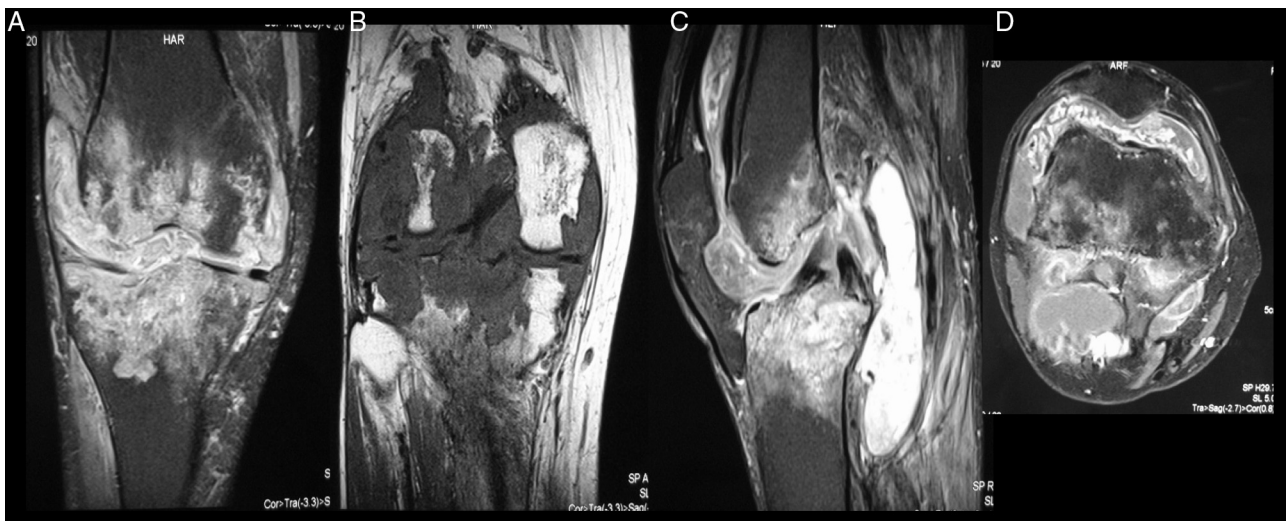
Magnetic resonance imaging of a knee with diffuse pigmented villonodular synovitis of the knee. A and B, coronal cut in T1; C, sagittal section in T1; D, T1 axial cut with areas of diffuse synovitis with tibial and femoral bone invasion, resulting in significant joint destruction.
